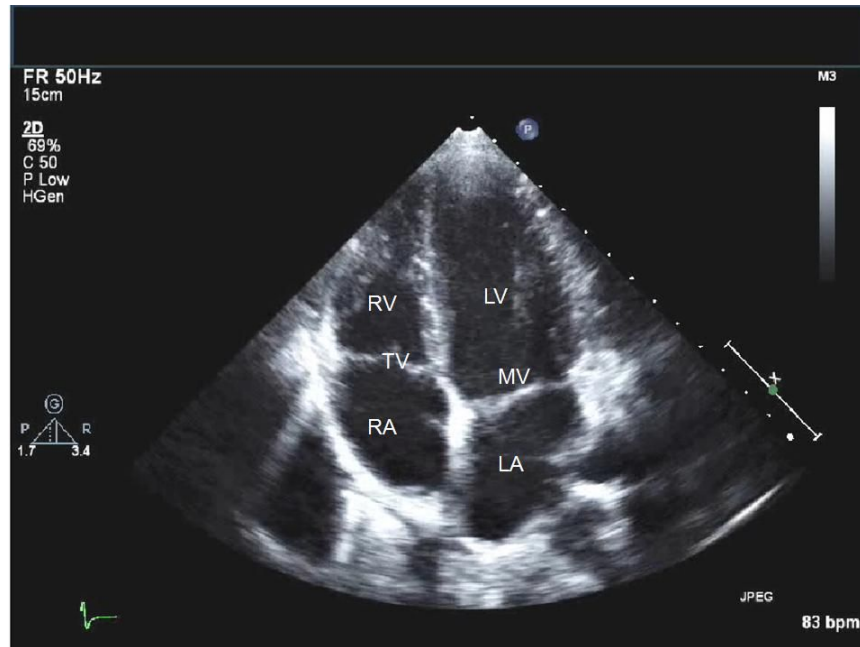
An echocardiogram of the heart. Four chamber view. Two ventricles and two atria are seen. The image is downloaded from 'echocardiographer.org' in December 2017.
